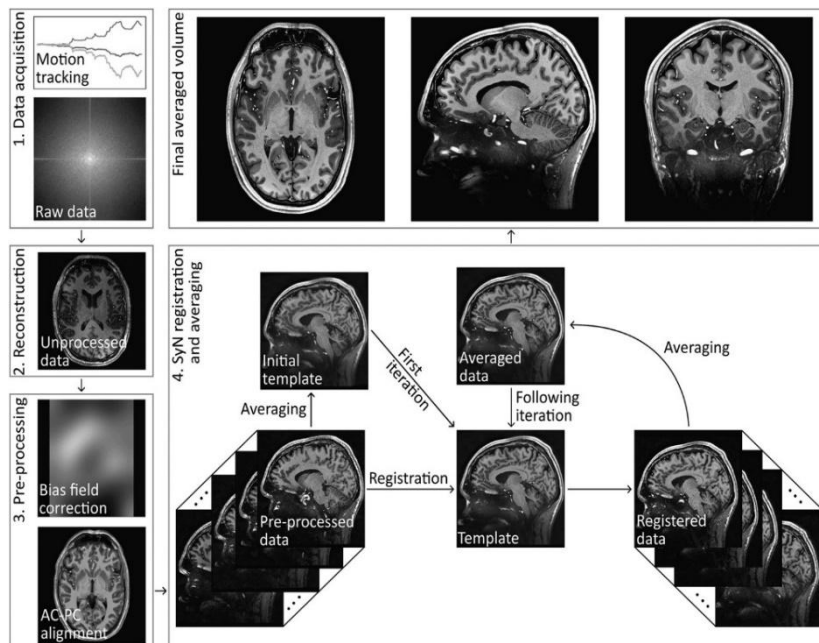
MRI scan image pre-processing.
